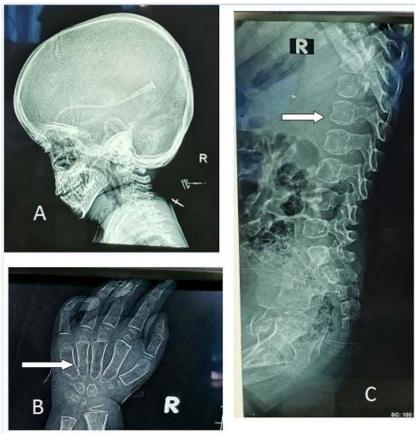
Dysostosis multiplex on x-ray: A- Macrocephaly. B- Proximal pointing of metacarpal bones (white arrow). C- Mild anterior-inferior vertebral body beaking (white arrow)
